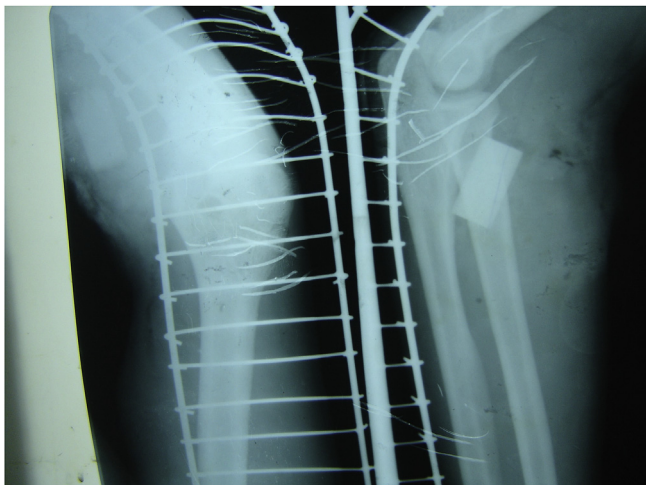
Radiograph of the above patient.
